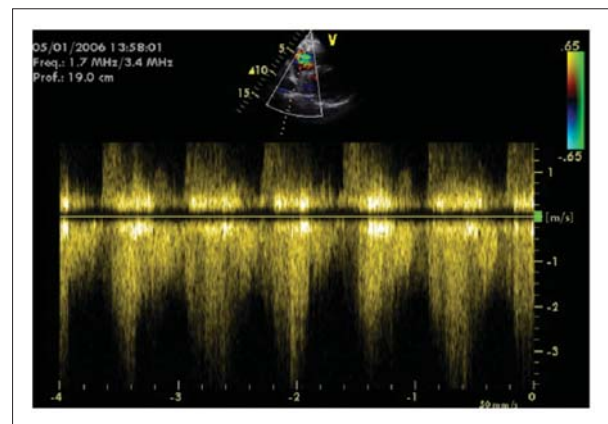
Doppler of fistula.
